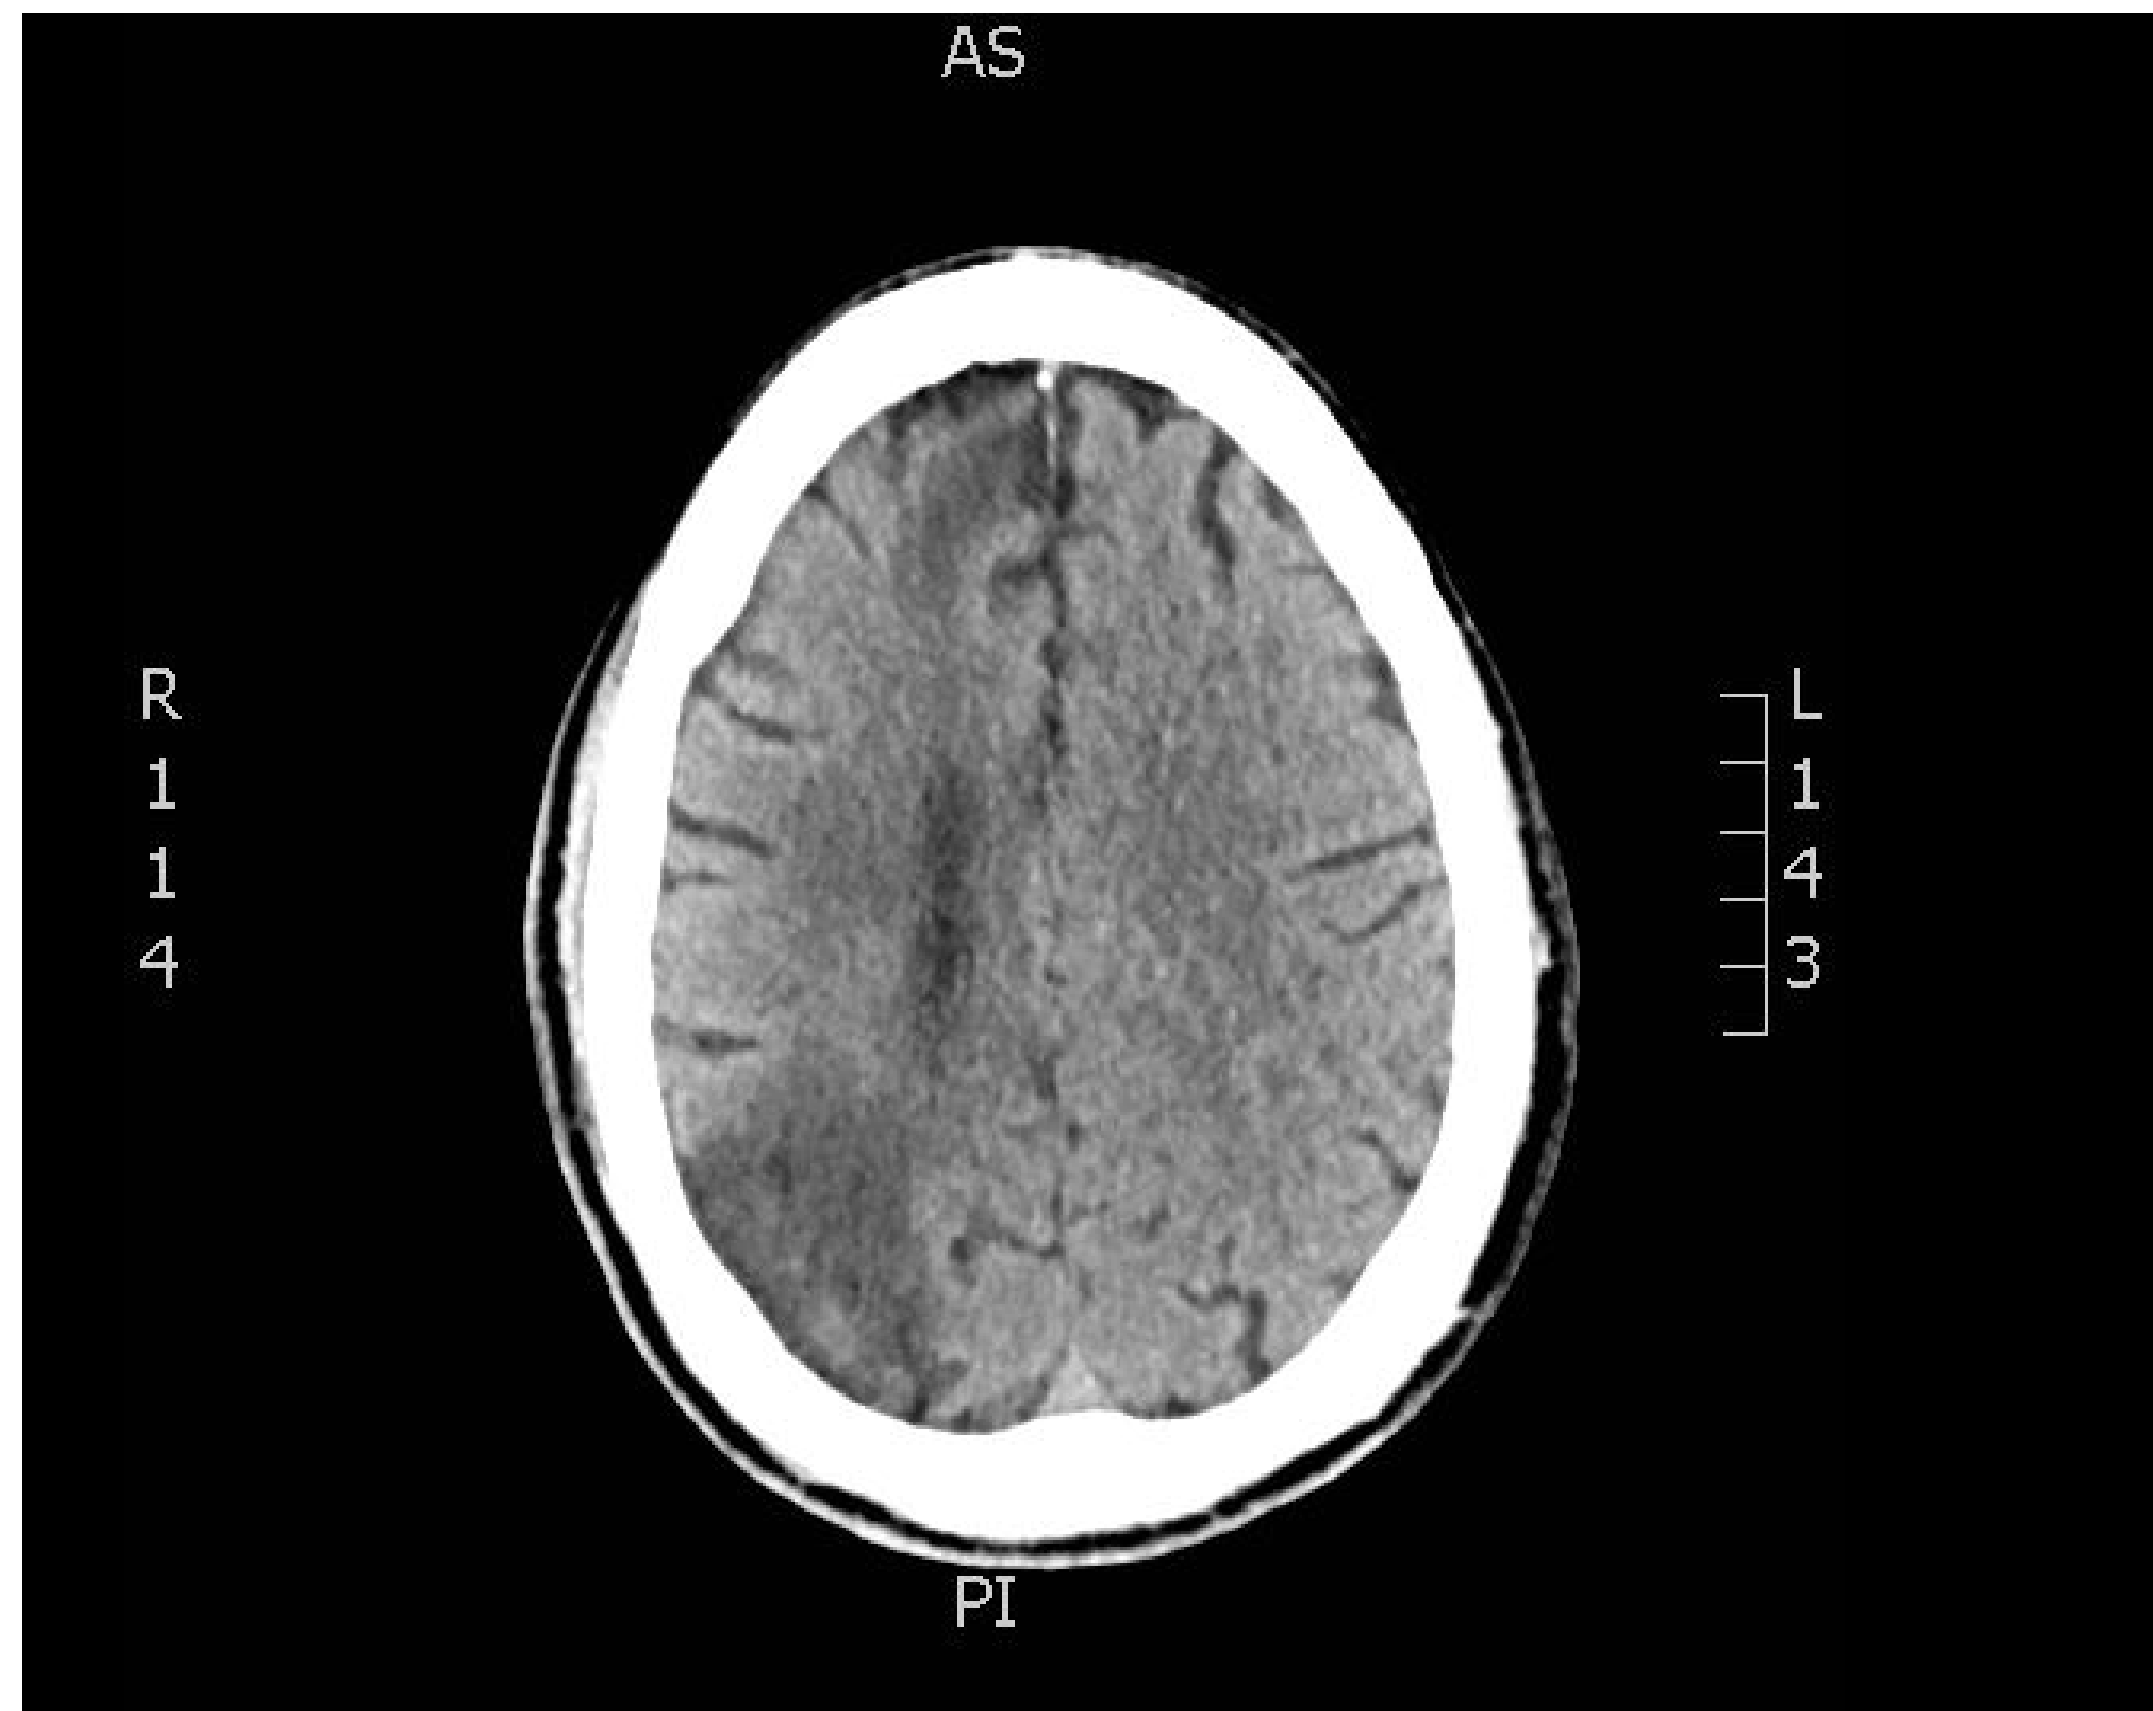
CT Scan depicting right sided stroke
